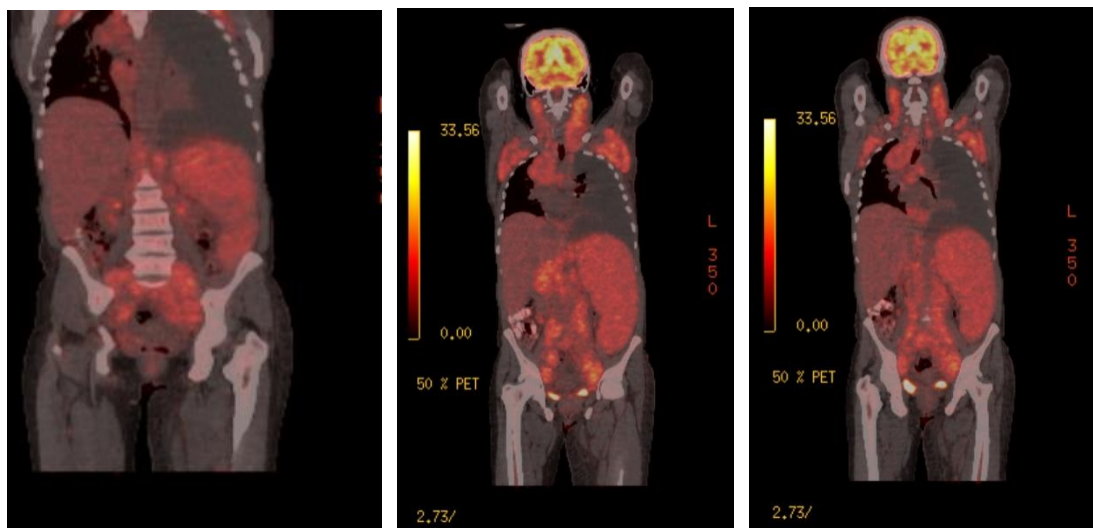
PET/CT images of the patient at the time of diagnosis (Involvement in almost all lymphatic tracts and spleen in the examination area, diffuse pleural effusion in the left hemithorax)
